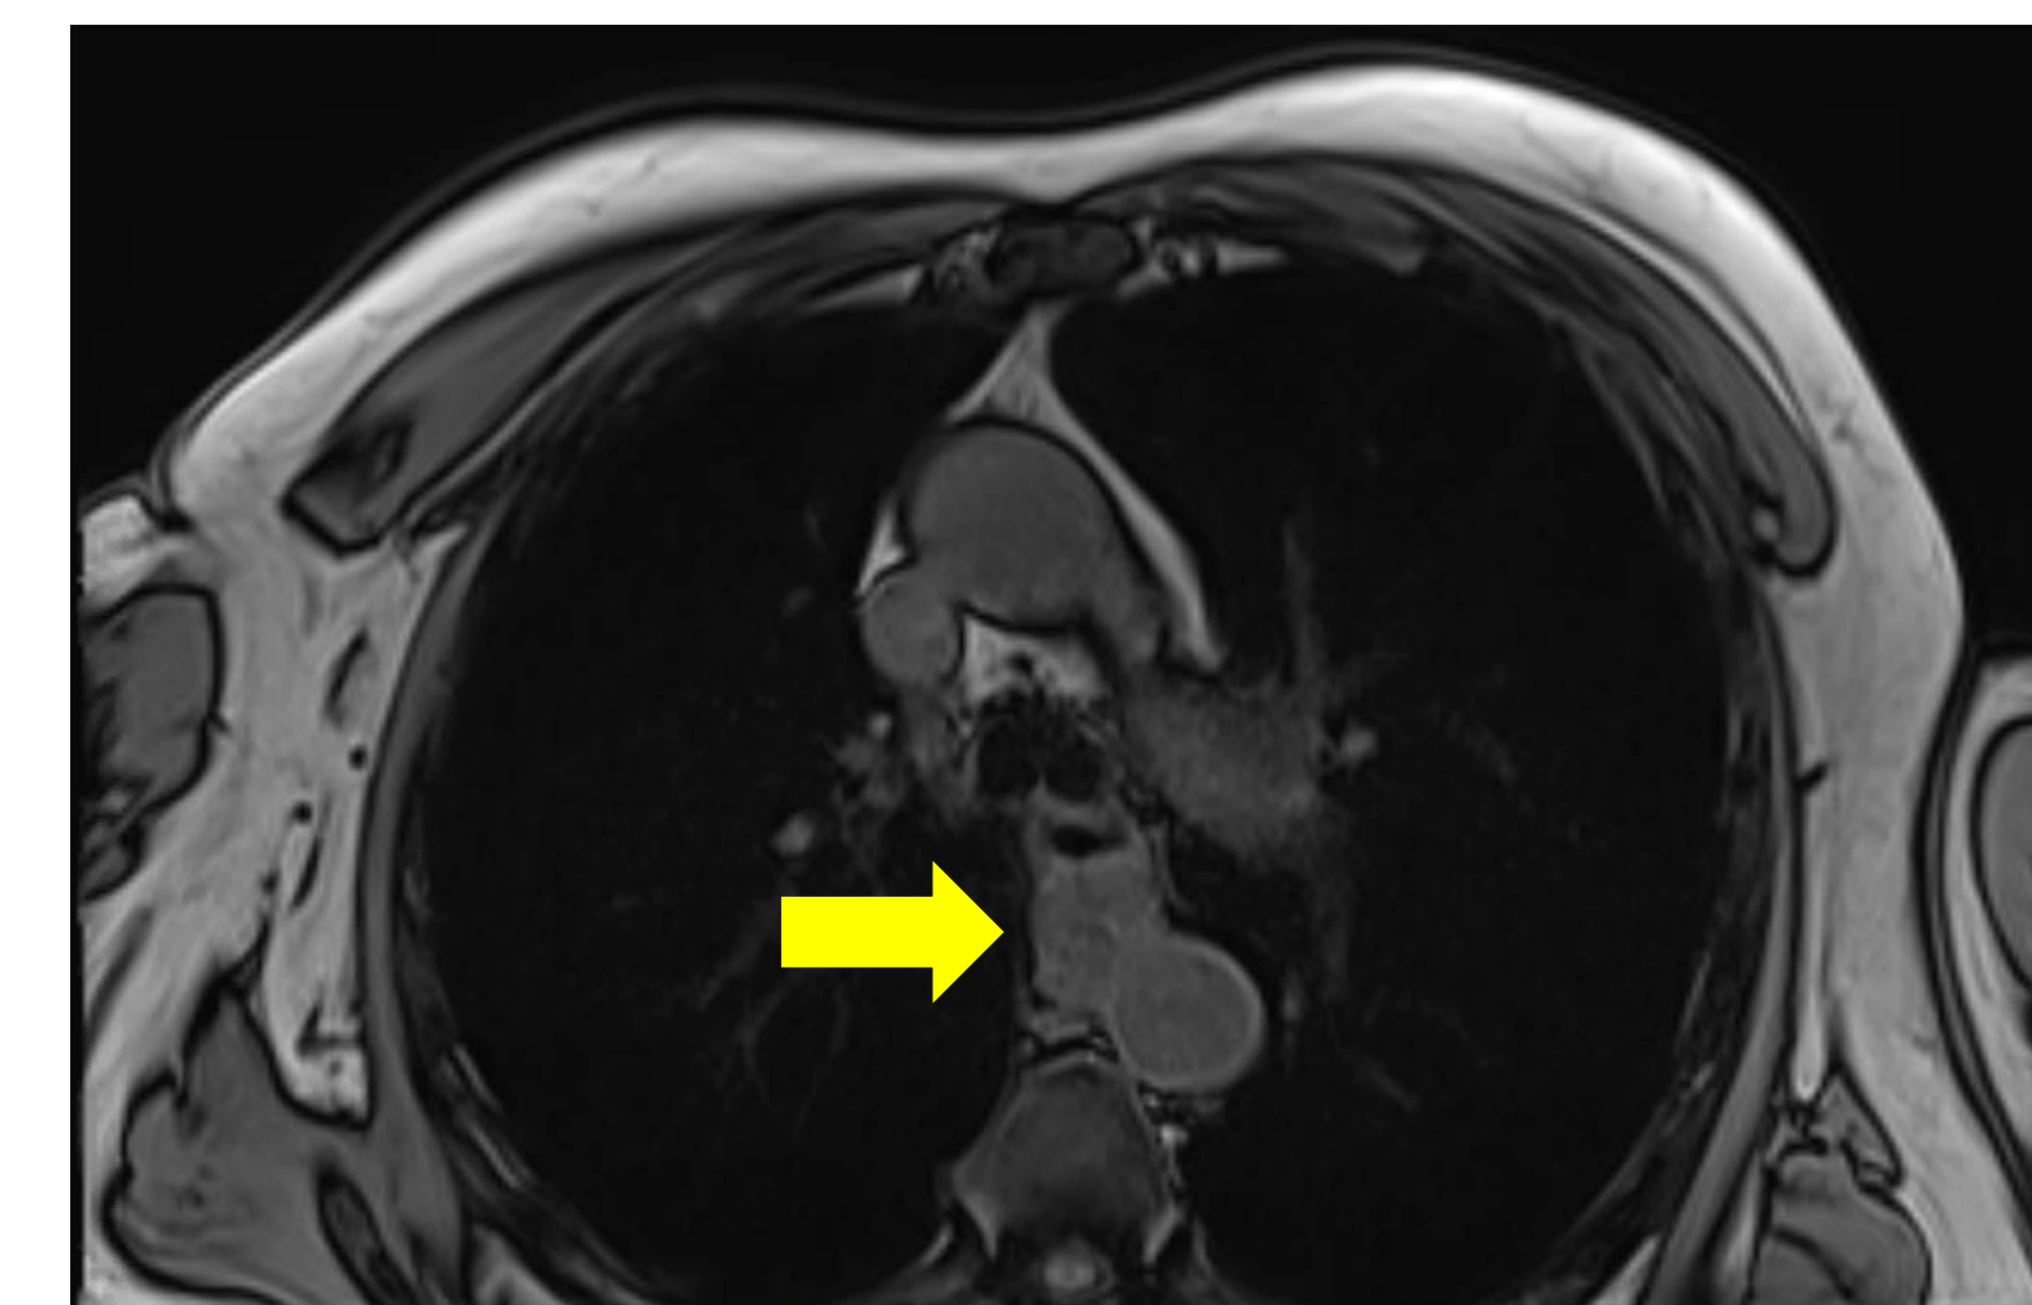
MRI notable for circumferential mass posterior to the esophagus
